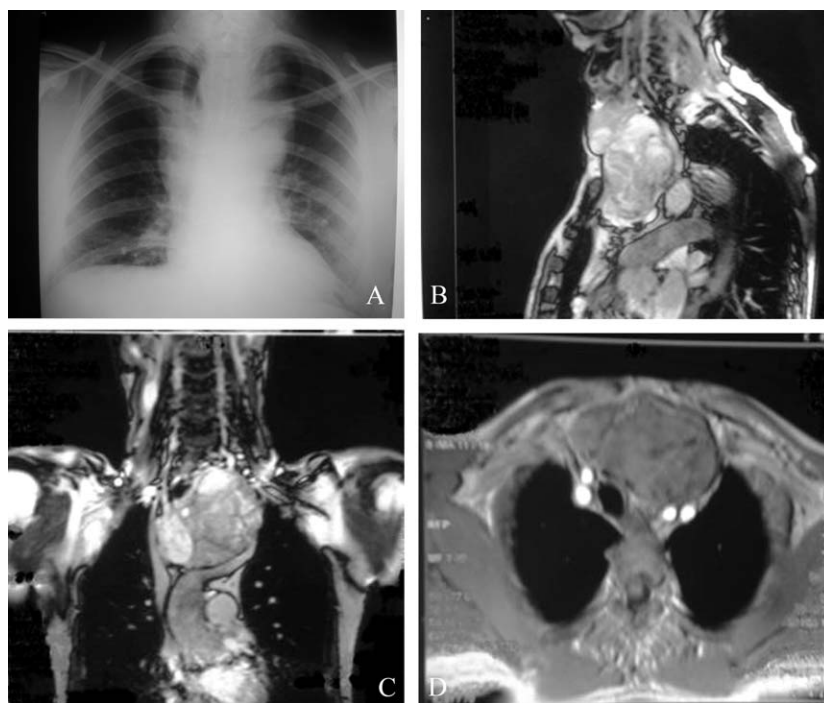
(A) Chest X-ray showing deviated trachea. (B) Sagittal plain CT scan showing substernal goiter extension in to the anterior mediastinum. (C) Coronal plain CT scan showing substernal goiter displacement mediastinal structures. (D) Axial plain CT scan showing substernal goiter.
